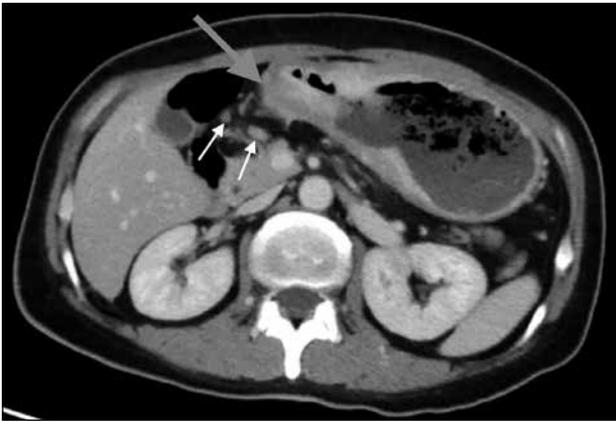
Gastric carcinoma in a 56-year-old woman. Contrast-enhanced computed tomography showing eccentric mural thickening of the gastric antrum (grey arrow). Perigastric nodal metastases are noted (white arrows).
